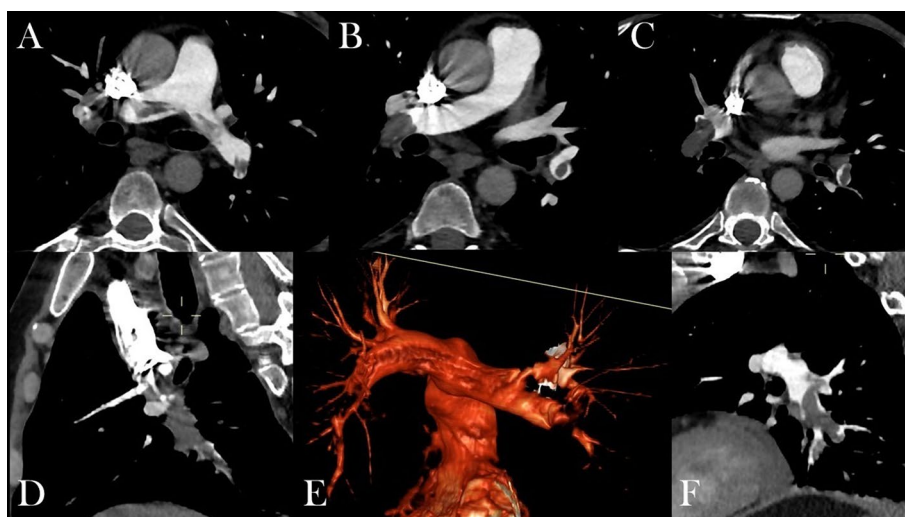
Axial (A, B, and C) and sagittal (D and F) CT angiography of pulmonary arteries shows extensive filling defects straddling the bifurcation of the pulmonary trunk, extending into the left and right pulmonary arteries. A volume rendering image of the pulmonary artery (E) shows amputation affecting the pulmonary artery in its lobar inferior branches bilaterally and an impression that straddles the bifurcation of the pulmonary trunk
